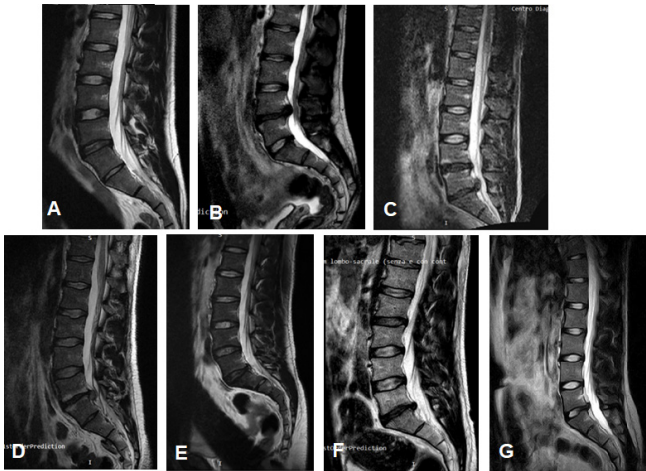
MRI of the patients.
